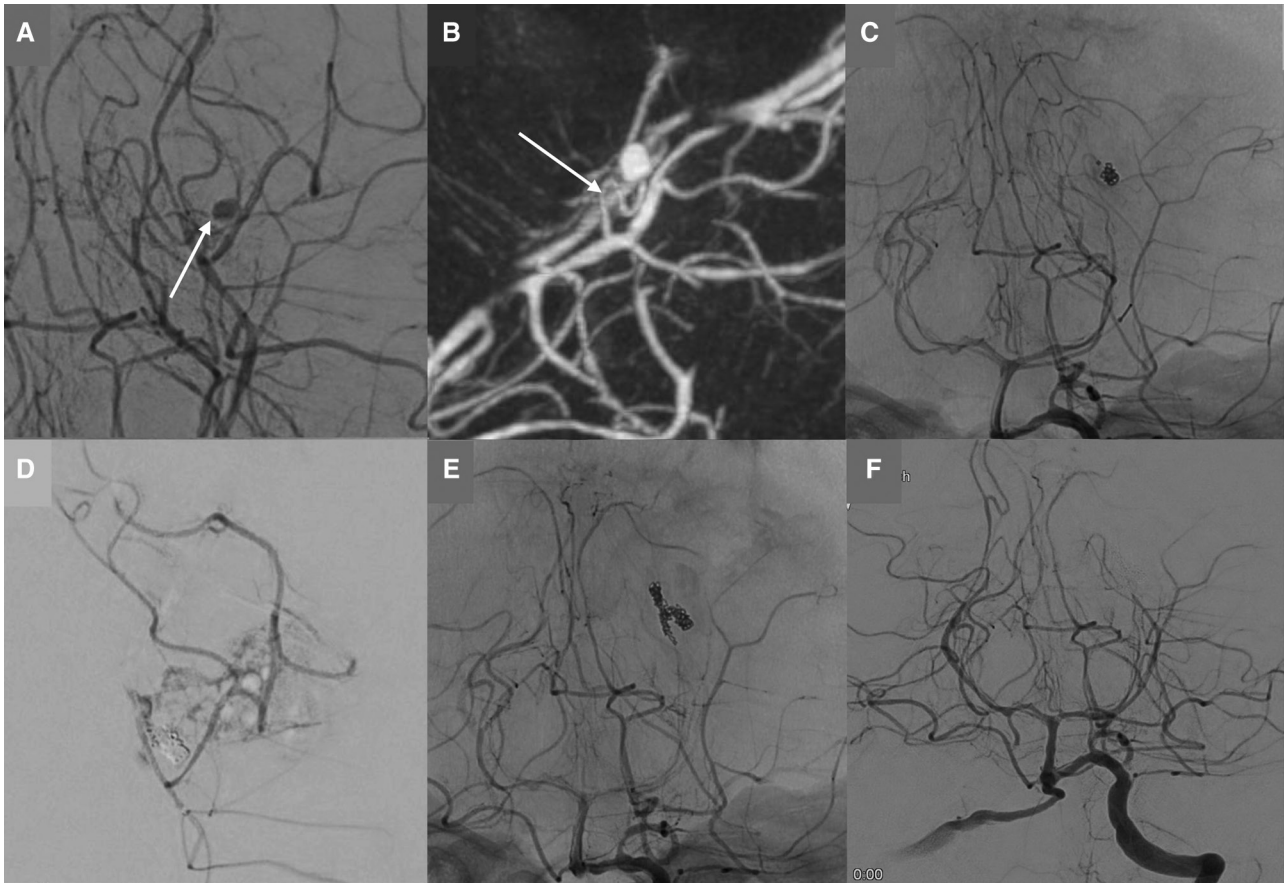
Intraoperative images. (A) DSA of the left vertebral artery (cranial 30°) before embolization shows severe stenosis of the parent artery (white arrow) just proximal to the contrast pooling, and no branches around the lesion. (B) Cone beam CT with undiluted contrast medium shows a tortuous lateral posterior choroidal artery (LPChA) (white arrow) proximal to the aneurysm. (C) Control left vertebral angiography after embolizing the aneurysm and LPChA. The left posterior cerebral artery (PCA) is difficult to see because of the microcatheter. (D) Injection from the microcatheter performed just after obtaining image C shows contrast medium extravasation. (E) Control left vertebral angiography after occlusion of the left PCA. Platinum coils are seen in both the LPChA and main trunk of the PCA. (F) Final control DSA of the left vertebral artery (cranial 30°). The main trunk of the left PSA is not evident.
